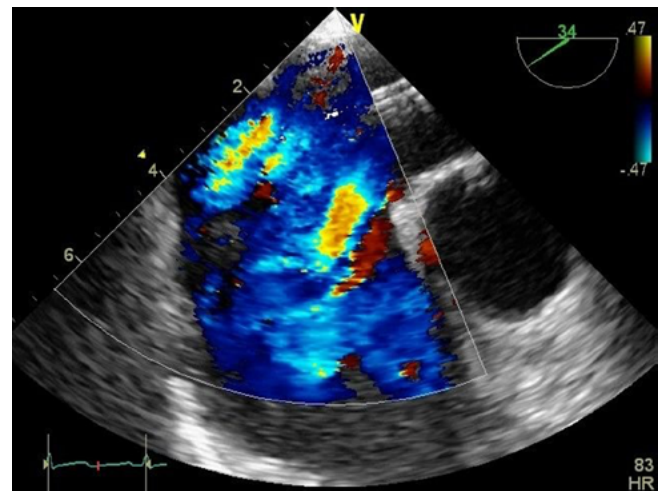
Transesophageal echocardiogram demonstrating a multifenestrated atrial septal defect with four openings.
